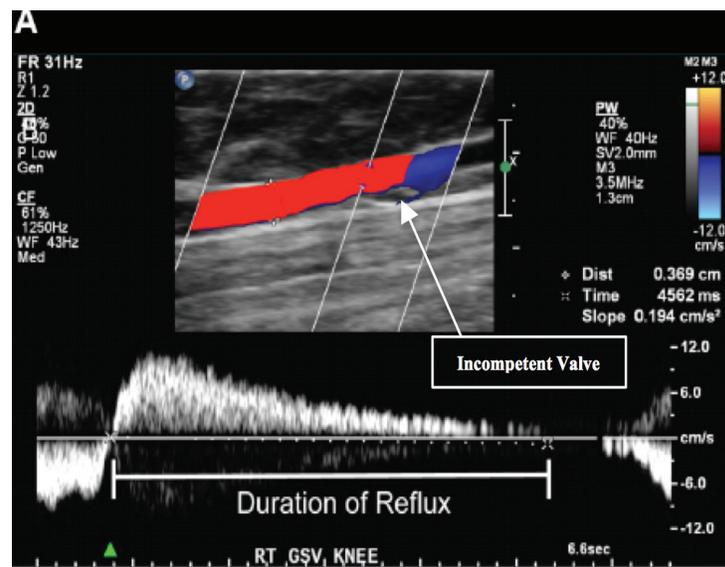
Color flow Doppler demonstrating reflux in the great saphenous vein (Note the change in color flow duplex, red indicates reflux).
